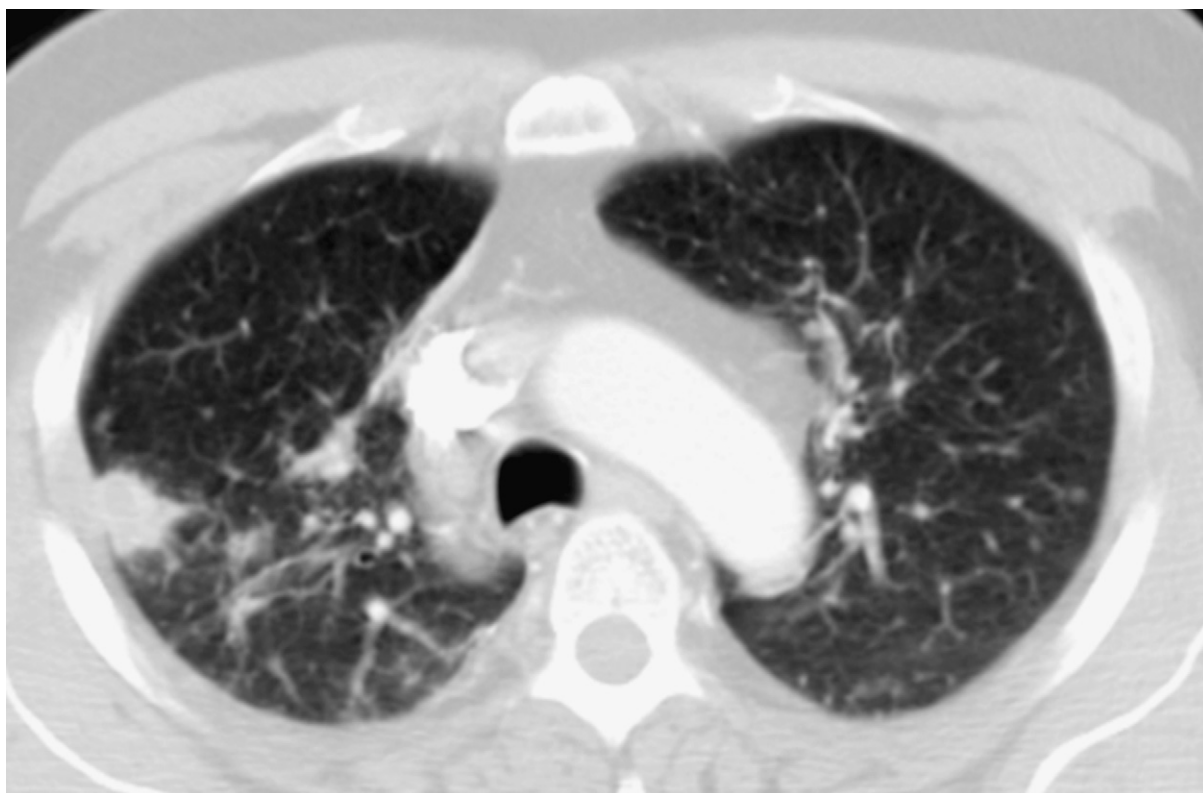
Chest CT showing a 2 cm × 1.3 cm irregular nodule in the right upper lobe. There are innumerable bilateral subcentimeter parenchymal nodules.
